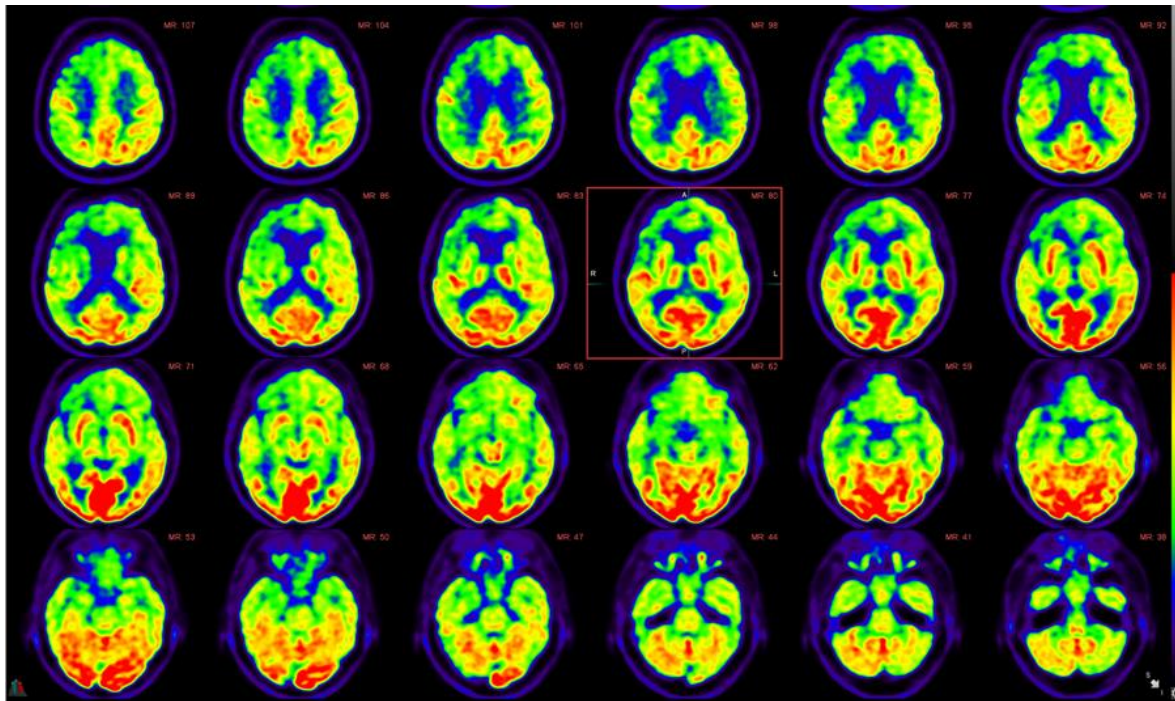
Serial fusion FDG-PET and FLAIR axial views of a 73-year-old female with metabolic and structural imaging findings suggestive of underlying behavioral variant frontotemporal dementia, with associated crossed cerebellar diaschisis. Specifically, there is abnormal FDG distribution pattern with significantly decreased radiotracer uptake primarily in the right frontal lobe and to a lesser degree in the right temporal lobe, including the anterior cingulate gyrus, with corresponding striking hypometabolism in the contralateral left cerebellar hemisphere, findings consistent with crossed cerebellar diaschisis.
